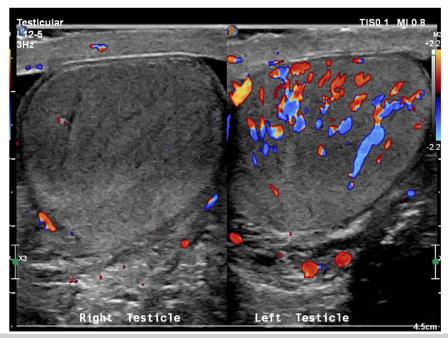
Testicular ultrasound scan showing minimal to no color flow in the right testis, a hyperemic right scrotal wall and peritesticular tissues, and a normal ultrasound appearance of the left testis.
